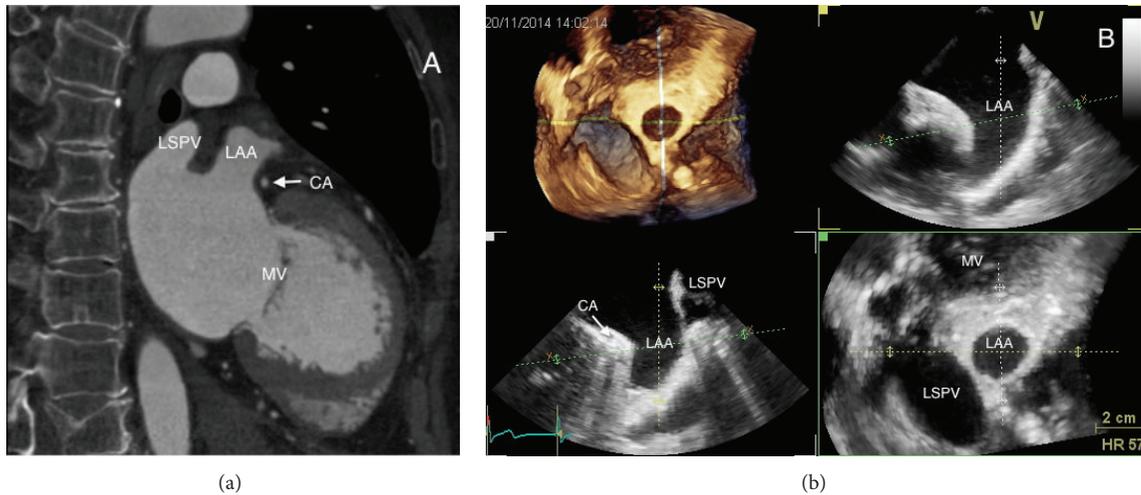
Left appendage anatomical relationship, as seen with cardiac CT scan (a) and 3D transesophageal echocardiography (b). LAA: left atrial appendage; LSPV: left superior pulmonary vein; CA: circumflex artery; MV: mitral valve.
